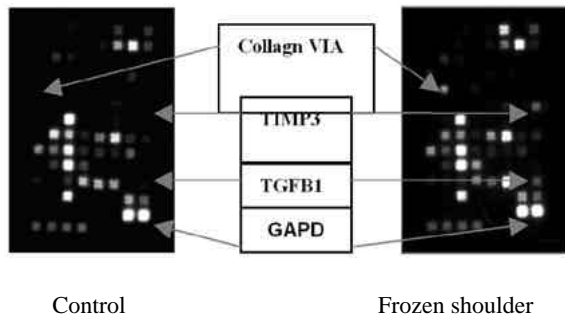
One sample of x-ray films of chemiluminescent detection membrane for Human Extracellular Matrix & Adhesion Molecule Gene Array. Collagen VIA = Collagen 6 alpha, TIMP 3 = Tissue Inhibitor of Metalloproteinase 3, TGF B1 = Transforming Growth Factor beta 1 GAPD = Glyceraldehyde-3-phosphate dehydrogenase.
